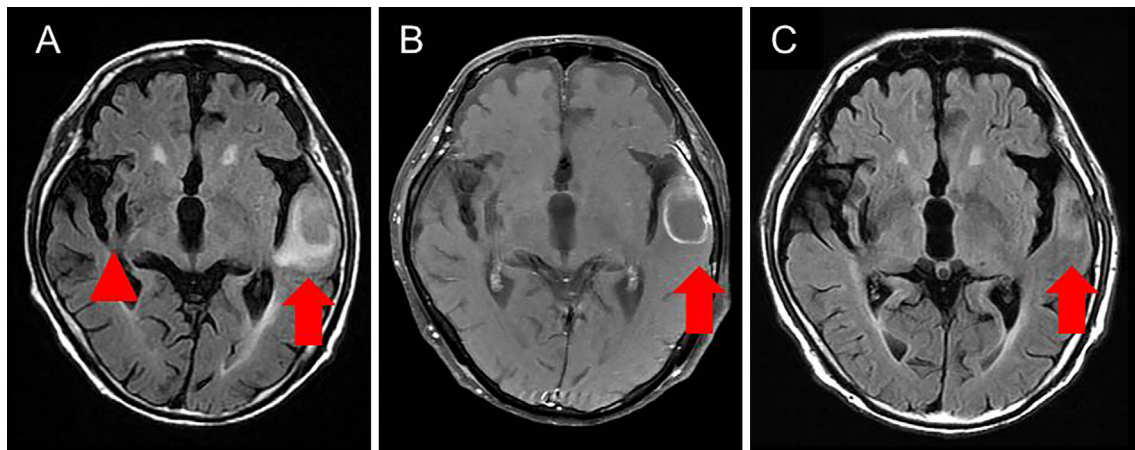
Brain magnetic resonance imaging at admission (A and B) and after the treatment (C). (A) Fluid-attenuated inversion recovery (FLAIR) images show old cerebral hemorrhaging in the right insular cortex (arrowhead) and a cystic mass surrounded by brain edema in the left superior temporal gyrus (the temporal operculum) (the arrow). (B) T1-weighted imaging with gadolinium enhancement showed ring-enhancing cystic mass lesions (arrow), confirming the presence of a brain abscess. (C) FLAIR images obtained after the treatment show that the cystic mass had almost disappeared (arrow).
